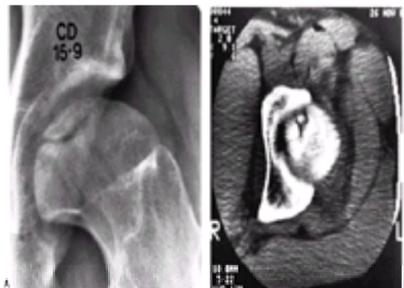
A: A 15-year-old boy, with onset of disease at 8.5 years of age, returned to the physician with pain and synovitis. Anteroposterior radiograph demonstrates osteochondritis of the femoral head. B: Computed tomographic scan shows multiple fragments that appear as one on the radiograph.
